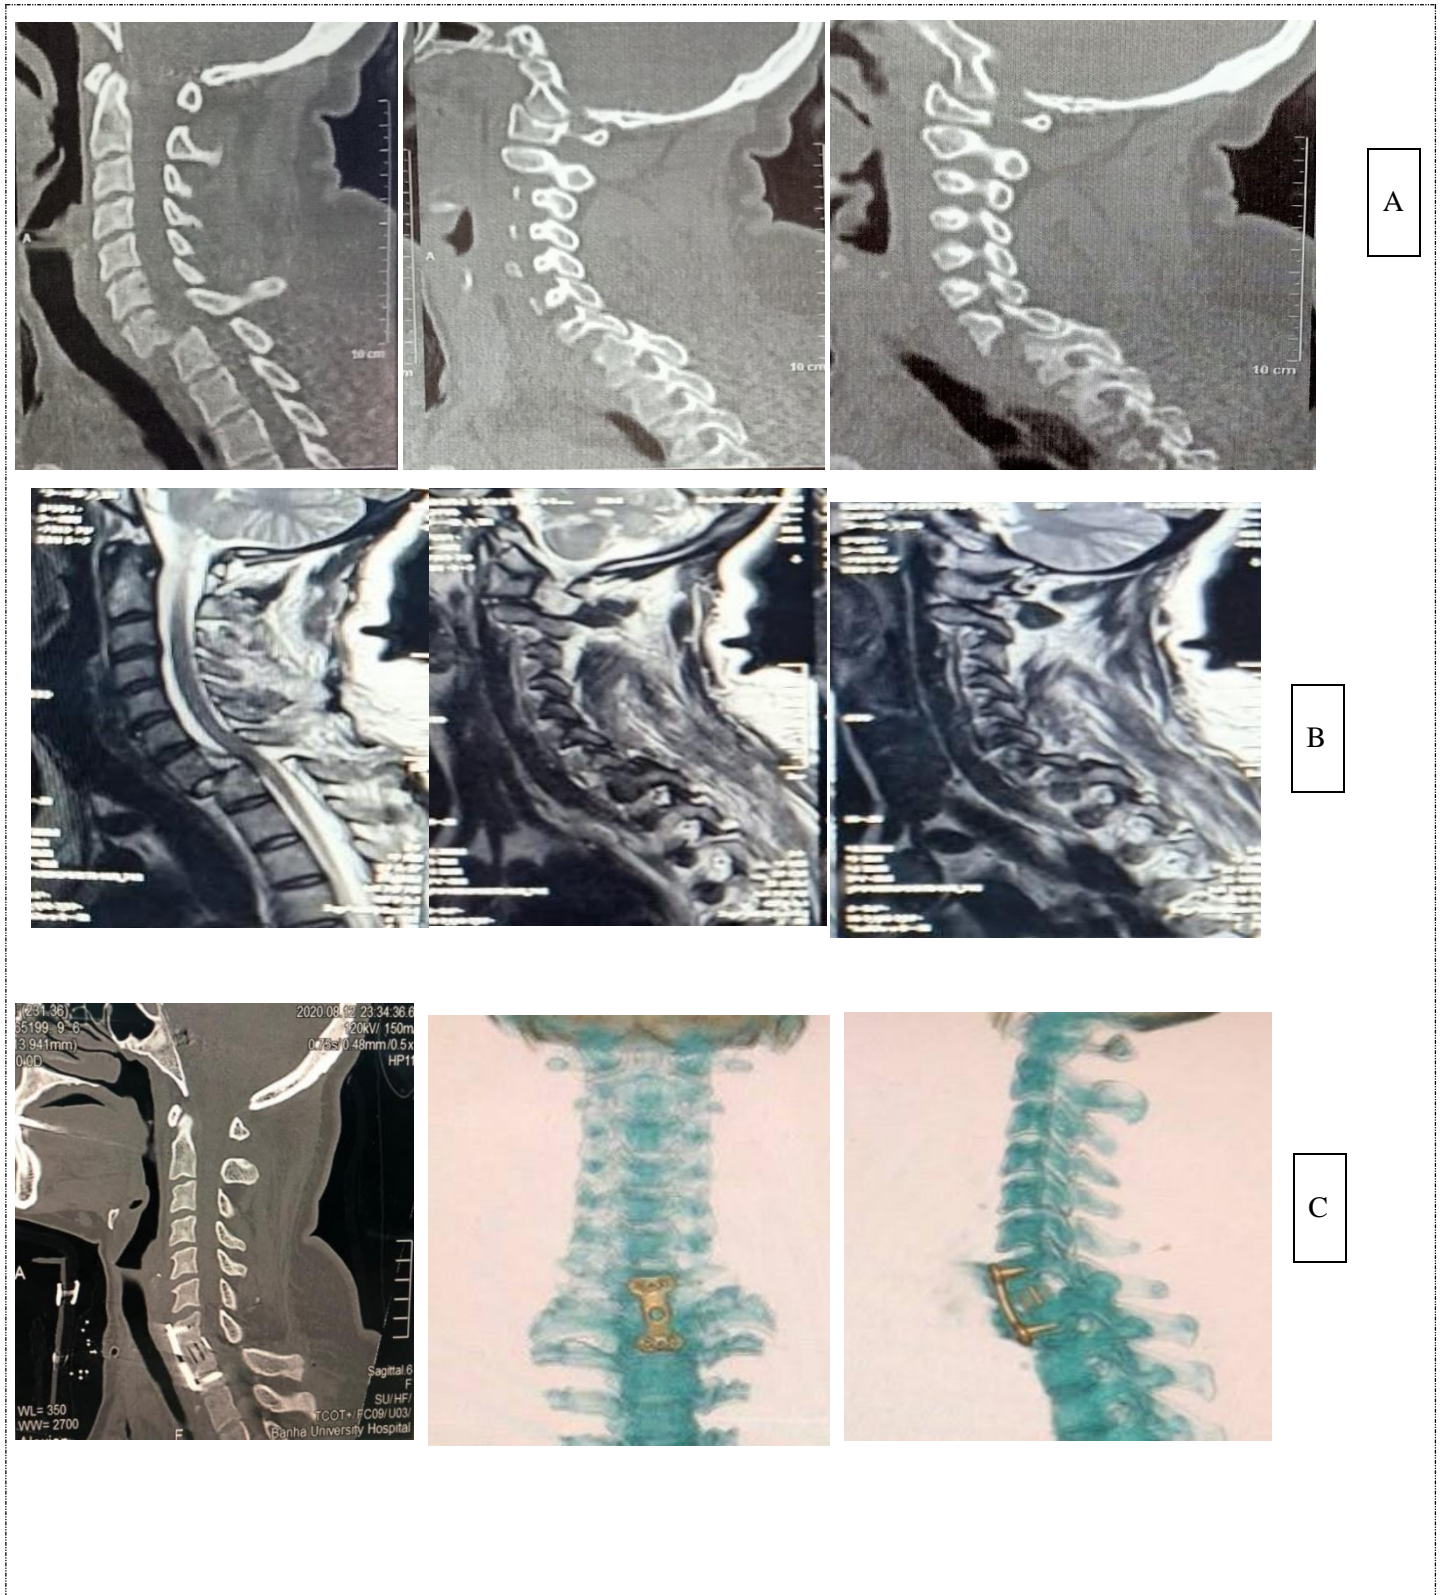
A: CT cervical spine with post-traumatic C7-D1 subluxation with bilateral locked facet (B): MRI T2 cervical spine with post-traumatic C7-D1 subluxation with the bilateral locked facet with G0 signal intensity. (C): post-operative CT cervical spine with discectomy, cage insertion with plate and screws with facet unlocking
